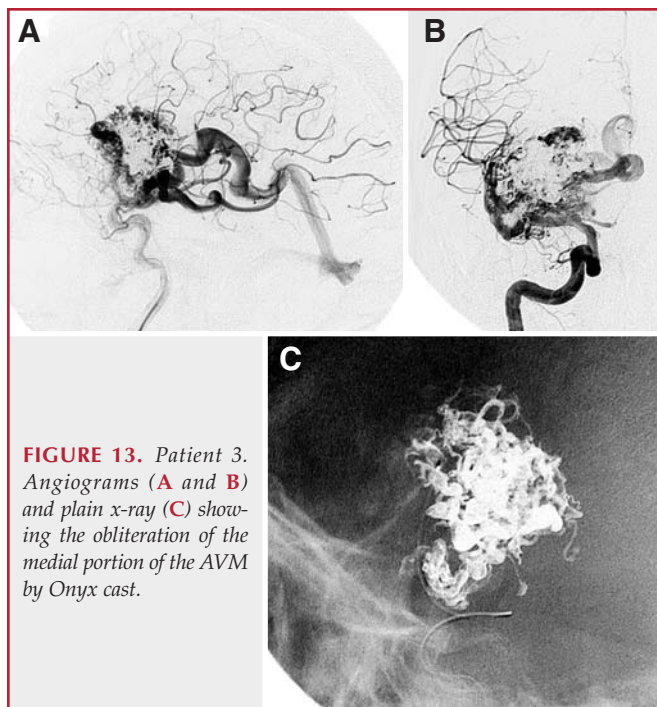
Patient 3. Angiograms (A and B) and plain x-ray (C) showing the obliteration of the medial portion of the AVM by Onyx cast.
